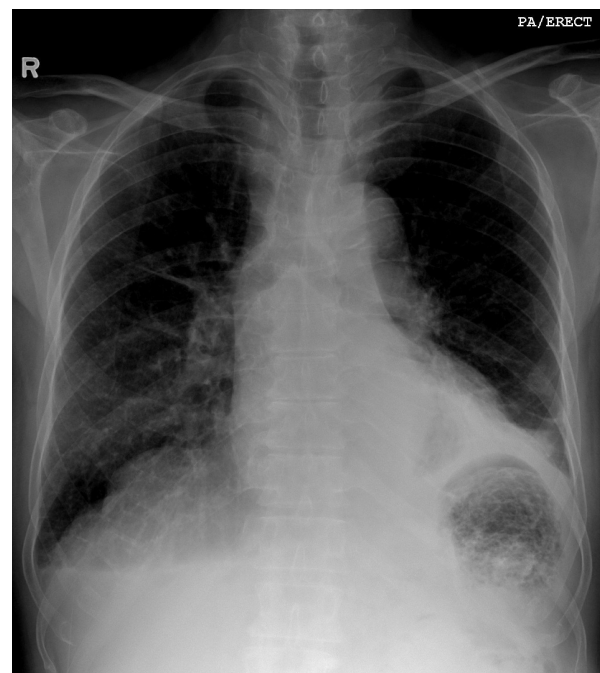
Chest X-ray showing left side pleural effusion and atelectasis
